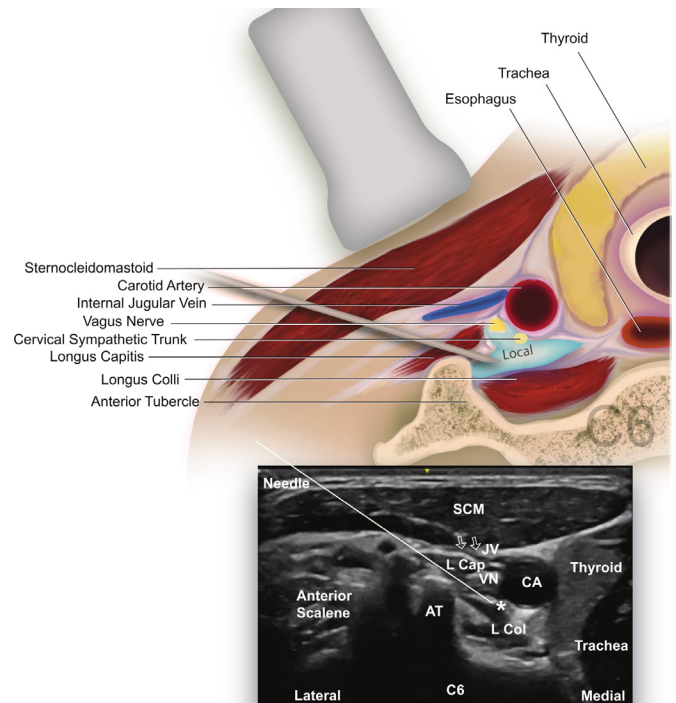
Cross-sectional view of the anatomical and ultrasound image structures at the sixth cervical vertebrae level where the block is commonly performed. The short axis ultrasonogram at C6 shows: SCM, sternocleidomastoid muscle; V, vagus nerve; CA, carotid artery; JV, compressed internal jugular vein (hollow arrows); * indicates the anatomical location where the cervical sympathetic trunk lies, not visualized with ultrasound imaging. The needle advances at the level of the anterior tubercle (AT) to locate the cervical sympathetic trunk at the middle cervical ganglion located between the longus capitis muscle (L Cap) and the longus colli muscle (L Col).
